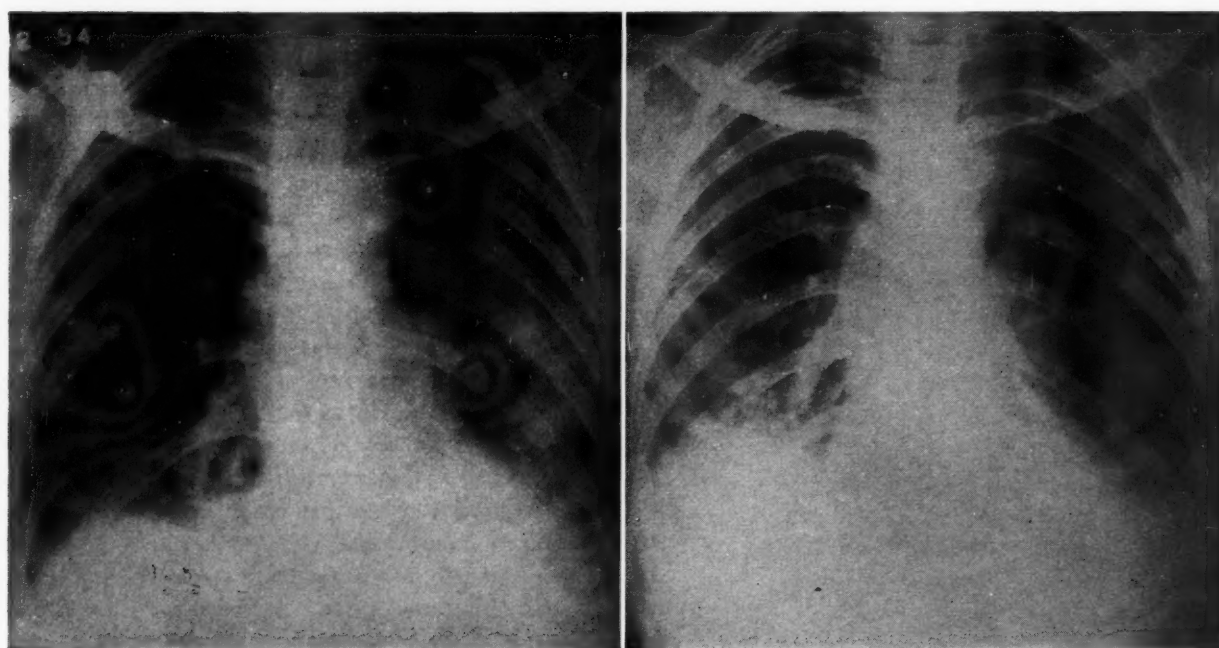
(Case III) A, chest x-ray, March 12, 1954; irregular, patchy infiltrations in both lower lobes, more numerous on the left where there is confluence of densities in the mid-lung field; there is pleural reaction at bases. B, chest x-ray, May 13, 1954; fine, diffuse reticulations permeating both lungs, chiefly the right; pleural reaction at bases more evident.
